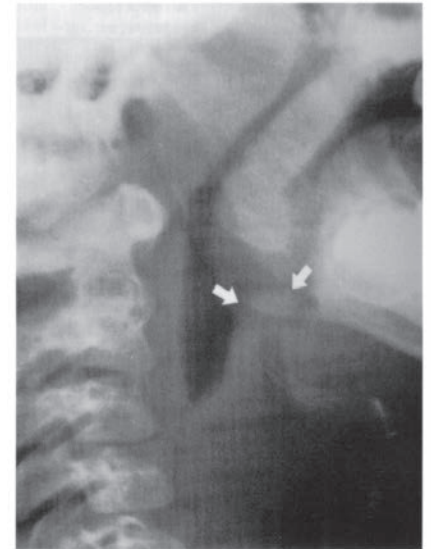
Radiograph of lateral soft tissue of neck demonstrating epiglottitis. Note the thickening of the epiglottic and aryepiglottic folds (arrows). (Reproduced, with permission, from Schwartz DT, Reisdorff BJ. *Emergency Radiology*. New York: McGraw-Hill, 2000: 608.)
